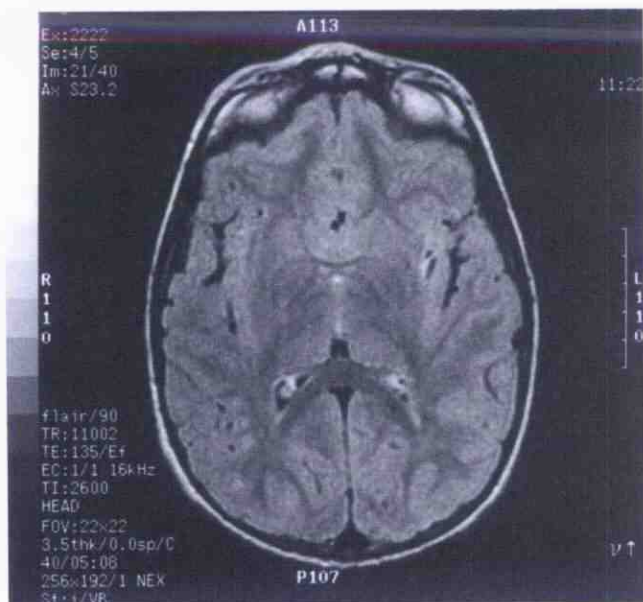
MRI demonstrating old infarct in left insular cortex.
